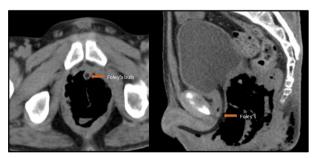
Axial and reconstructed sagittal Plain CT scan showing complete destruction of prostate with air pockets and fluid surrounding Foley's bulb in the region of prostatic urethra
